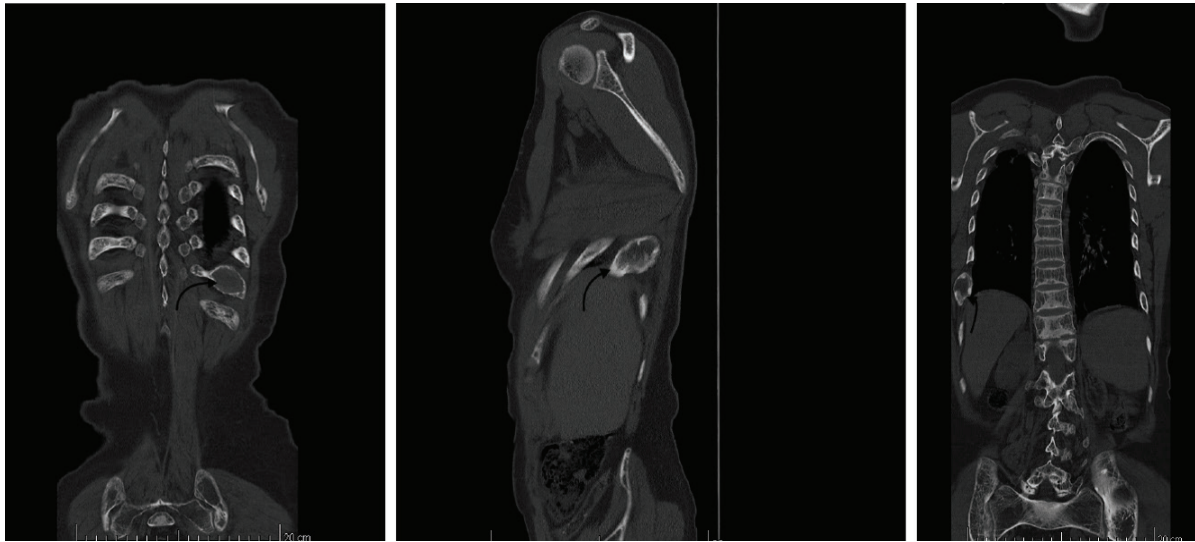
CT scan of the patient reveals an expansive sclerotic lesion with a width of 44 mm and a thickness of 20 mm at the posterolateral aspect of the right 9th rib
